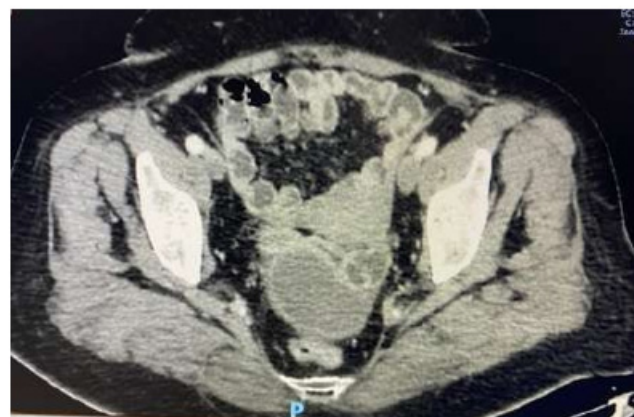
CT showing cystic pelvic mass
